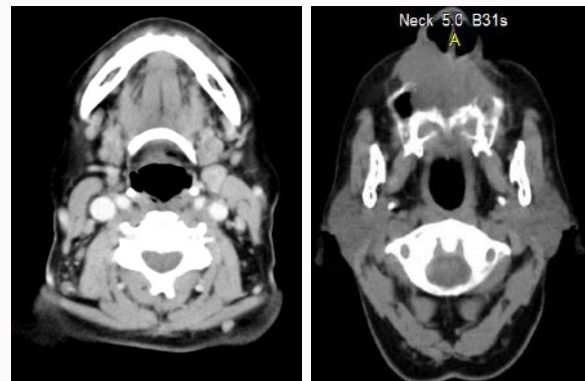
CT scan showing extent of lesion.
